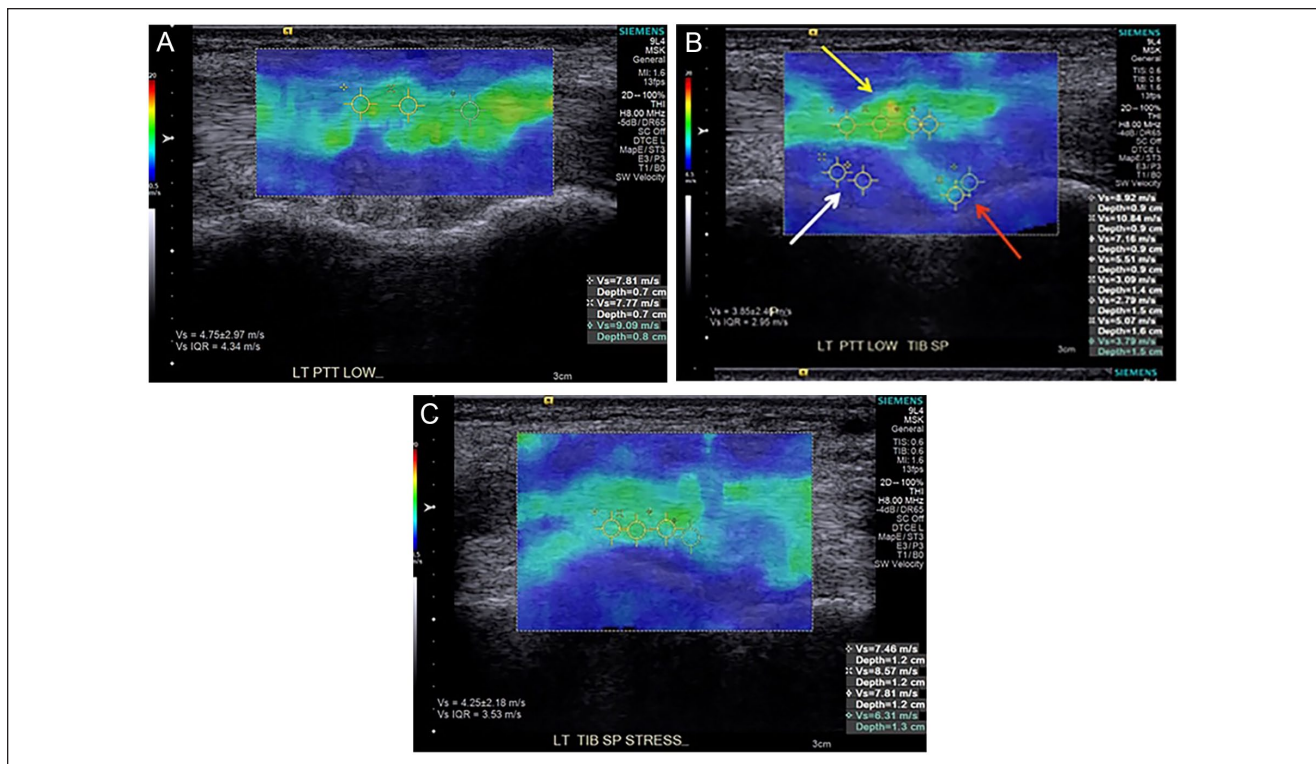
Representative ultrasound shear wave elastography images of the inframalleolar (lower) posterior tibial tendon (PTT), subjacent superficial deltoid ligament (tibiospring portion), and spring ligament (superomedial band) in an asymptomatic flatfoot, at rest (A and B) and under stress (C). The individual structures are identified in (B): long axis of the PTT (yellow arrow), tibiospring portion of the deltoid ligament (white arrow), and superomedial band of the spring ligament (red arrow). At rest note intermediate shear wave velocities (SWVs) in the PTT in green (A and B), lower SWVs in the tibiospring ligament in blue, and intermediate to low SWVs in the superomedial band of the spring ligament in lighter green and blue (B). Increased intermediate SWVs are seen in the tibiospring deltoid ligament in green when imaged under stress (C).
